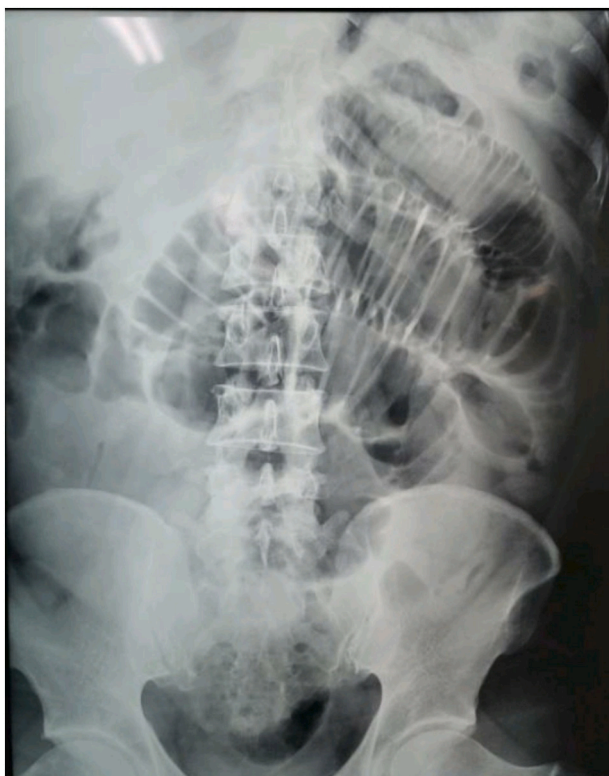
Plain abdominal X-ray showing dilated proximal peripheral bowel loops, and collapsed distal ileal/large bowel loops.
